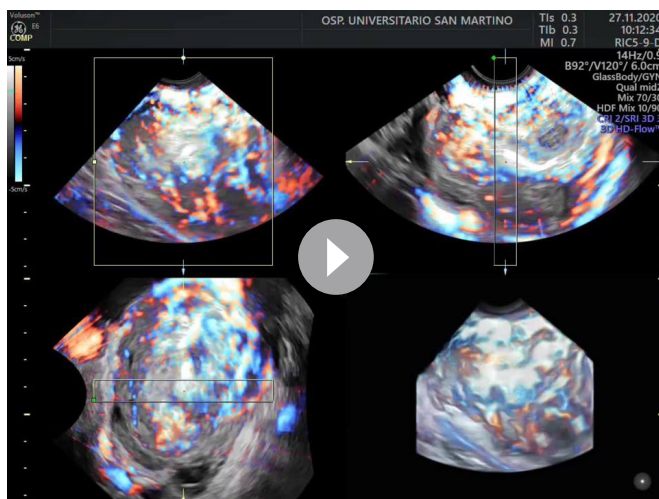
3D power Doppler image of the arteriovenous vessels inside the tumour. The mass appears almost completely consisting of vessels.
